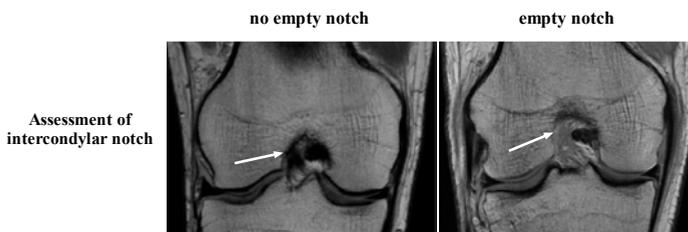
Assessment of intercondylar notch (arrow) (abnormal = empty notch). MRI sequence: coronal proton density weighted turbo spin echo (TSE); slice thickness, 3 mm; repetition time (TR)/time echo (TE), 2700/27 ms.
